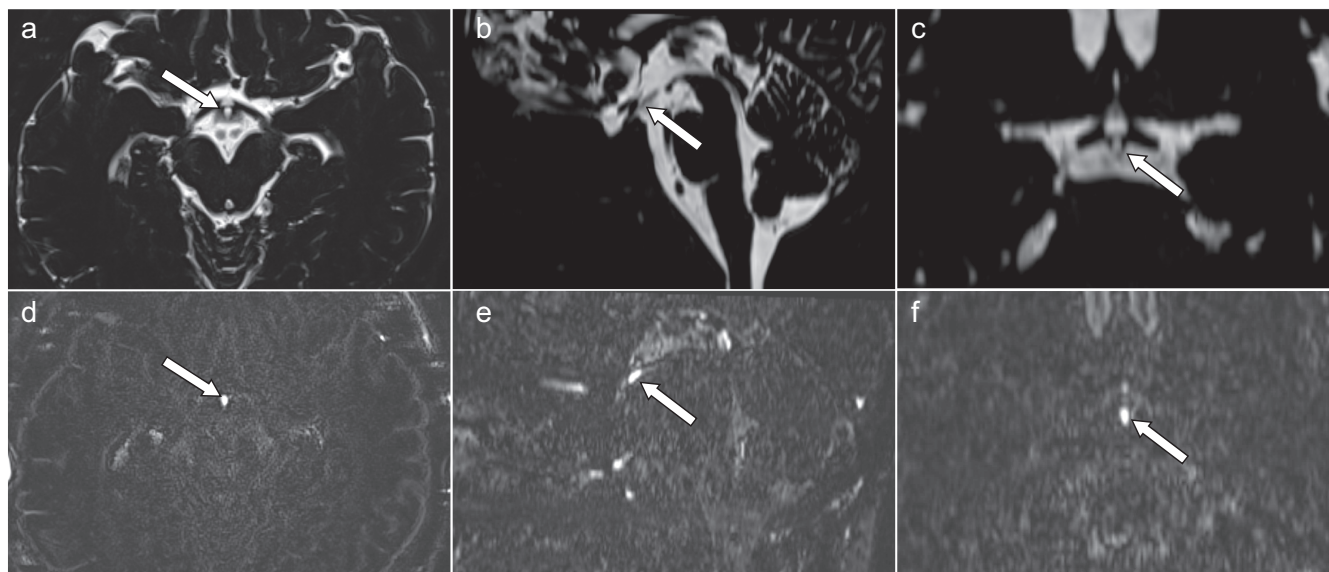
Contrast enhancement of the infundibular recess. The infundibular recess is hyperintense on axial (a, arrow), midsagittal reformatted (b, arrow), and coronal reformatted (c, arrow) MRC. The infundibular recess shows contrast enhancement on axial (d, arrow), midsagittal reformatted (e, arrow), and coronal reformatted (f, arrow) postcontrast HT2-FLAIR. HT2-FLAIR, heavily T2-weighted 3D fluid-attenuated inversion recovery; MRC, MR cisternography.
